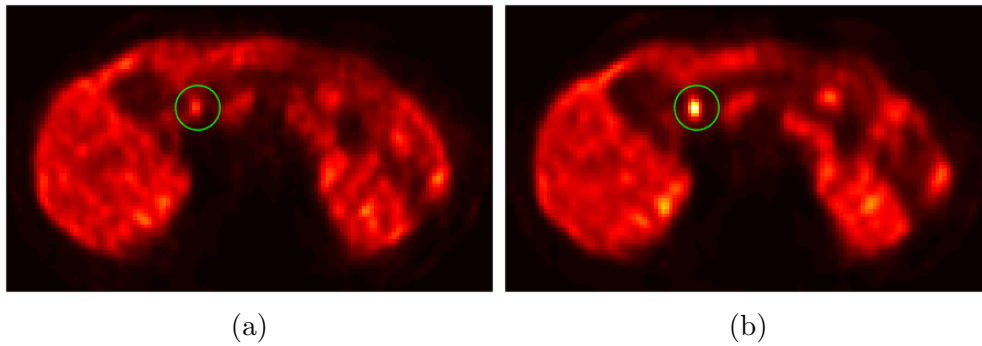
PET trans-axial slice images reconstructed from Siemens Biograph mMR PET/MRI data: (a) without motion correction and (b) with motion correction. The green circle indicates the location of a hot lesion. Reprint from Bousse et al. (2017).
